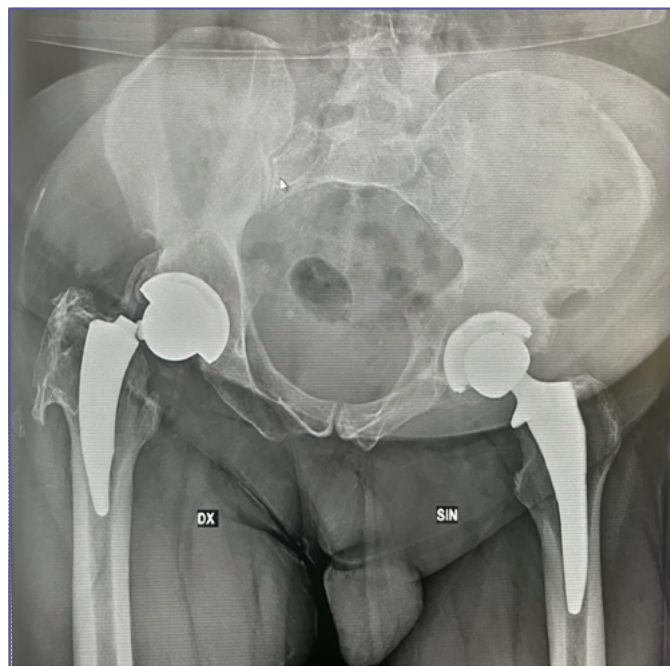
Pelvic X-ray showing fracture of the femoral stem near the neck.
